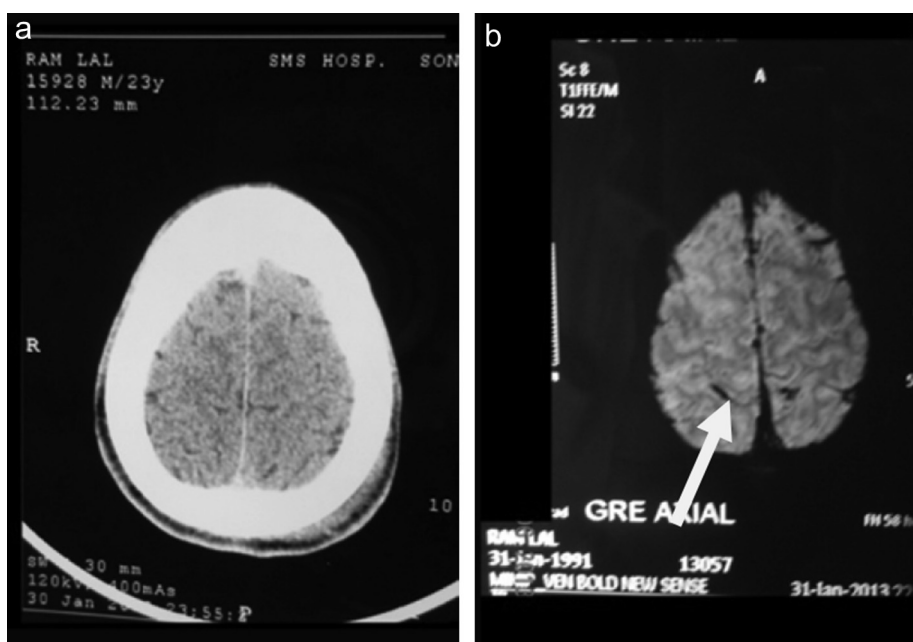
(a) Comparison of CT and (b) MRI (GRE) images showing fresh SAH in both parietal region.
